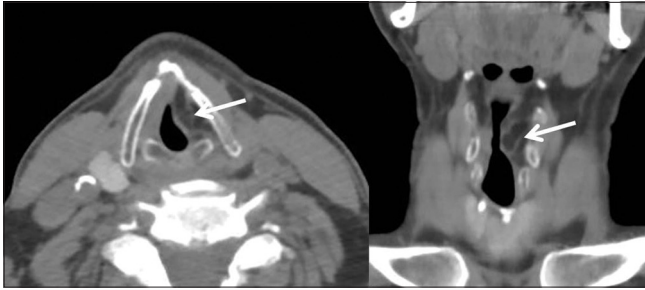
A 51-year-old male with an incidental lipoma of the left vocal folds. Non-contrast axial (left) and coronal (right) computed tomography images through the level of the larynx demonstrate a fat-attenuating lesion similar to adjacent subcutaneous fat (arrows) within the submucosal left vocal folds, which causes mild local mass effect. There is a thin septation within the lesion, but no nodularity.
